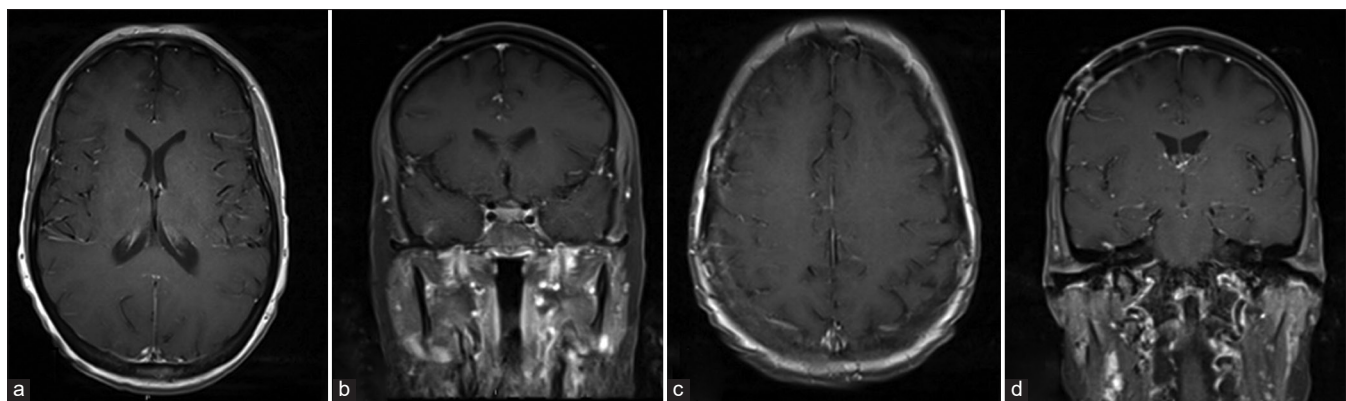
Follow-up postsurgical magnetic resonance imaging (a) axial (b) coronal section shows occipital lesions very small to measure. (c) Axial section shows resolution of the right temporal lesion. (d) Coronal section shows craniotomy site right frontal meningeal enhancement.
